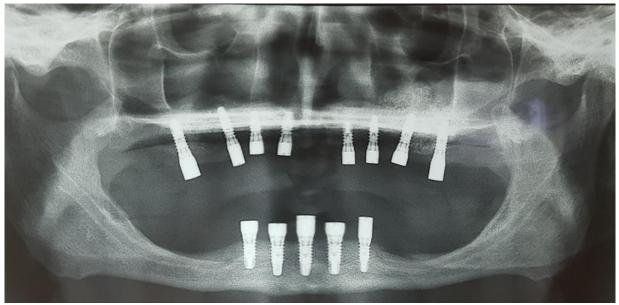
Post implant panoramic radiograph shows implants of upper and lower jaws in place
